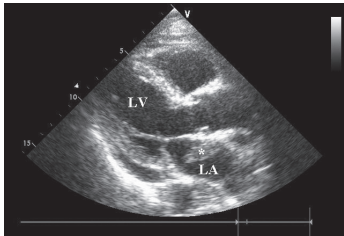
Transthoracic echocardiographic view showing left atrial thrombus by asterisk (LV=left ventricle, LA=left atrium).
